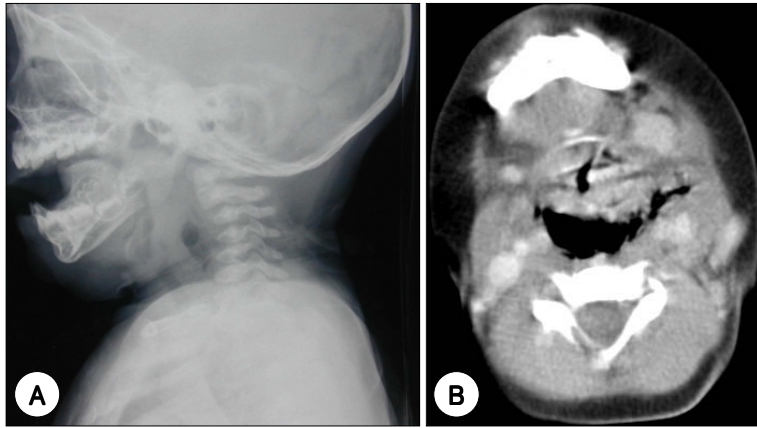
A : Lateral radiograph of the neck showing a retropharyngeal emphysema extending from the base of skull to the mediastinum. B : Computed tomographic scan shows a huge retropharyngeal air shadow around airway.
